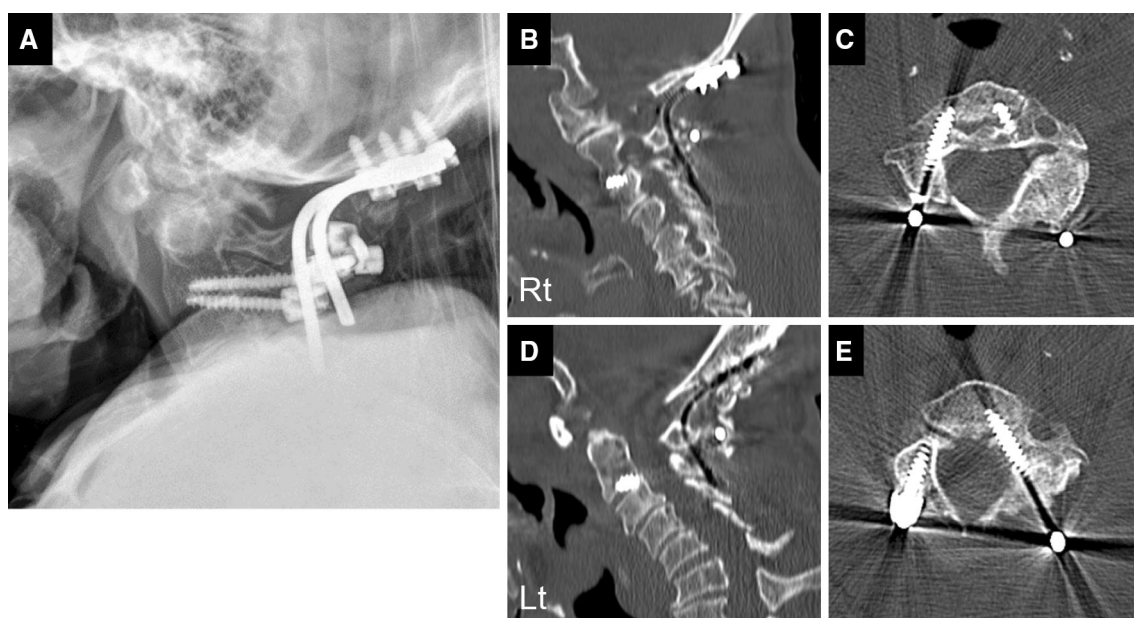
Postoperative lateral radiograph (a) and CT (b–e). Bilateral C2–3 transuncoversal screws were inserted through the pedicle and the uncoversal joint. *Rt* and *Lt* represent right and left sides, respectively
